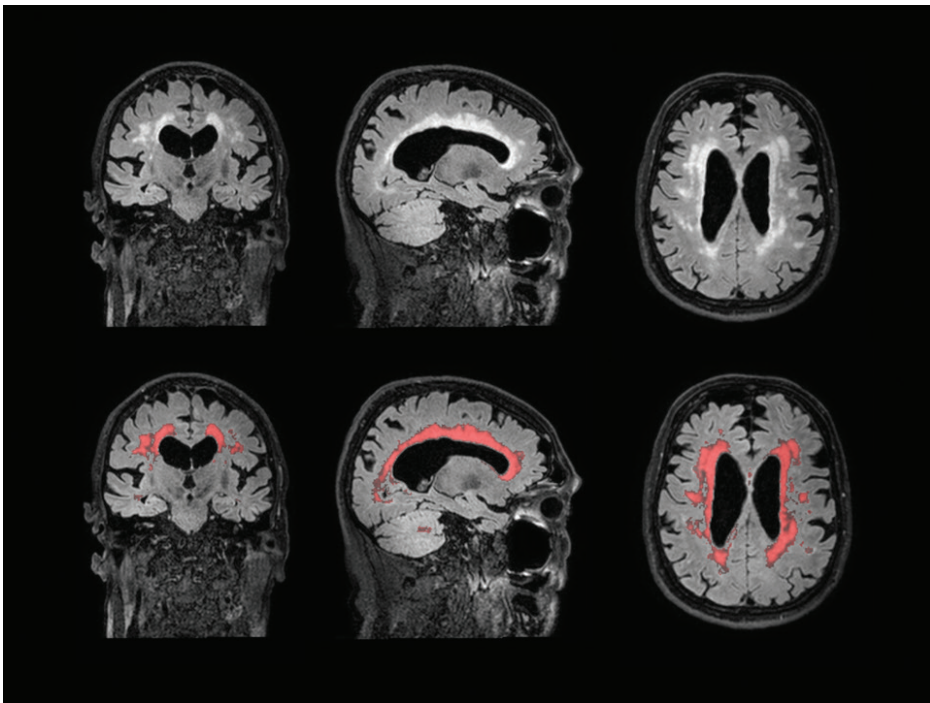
Example of a participant with a high WMH volume and complex WMH shape (top: original 3D FLAIR image; bottom: FLAIR image with overlay of the segmented WMH probability map in red).
